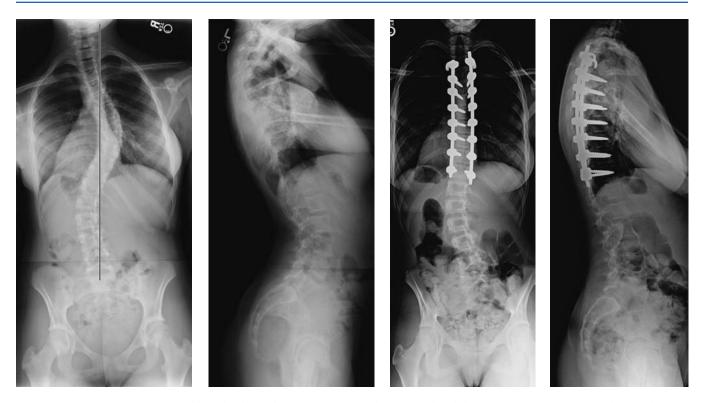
(*Continued*) (C,D) PA and lateral radiographs of a 15-yearold girl demonstrate a 52-degree thoracic and 40-degree thoracolumbar curve (Lenke type 1C deformity). The thoracic curve bends to 32 degrees (38% flexibility) and the lumbar curve bends to 10 degrees (75% flexibility). Selective posterior spinal instrumentation and fusion
